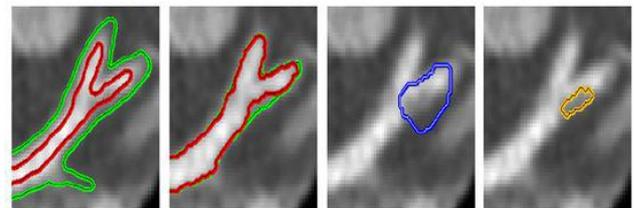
2D model for Plaque Detection Results on CTA imagery, reproduced from [12]. Red and green represents inner and outer surface. Blue represents ground-truth reference plaque and brown represents the detected plaque.
